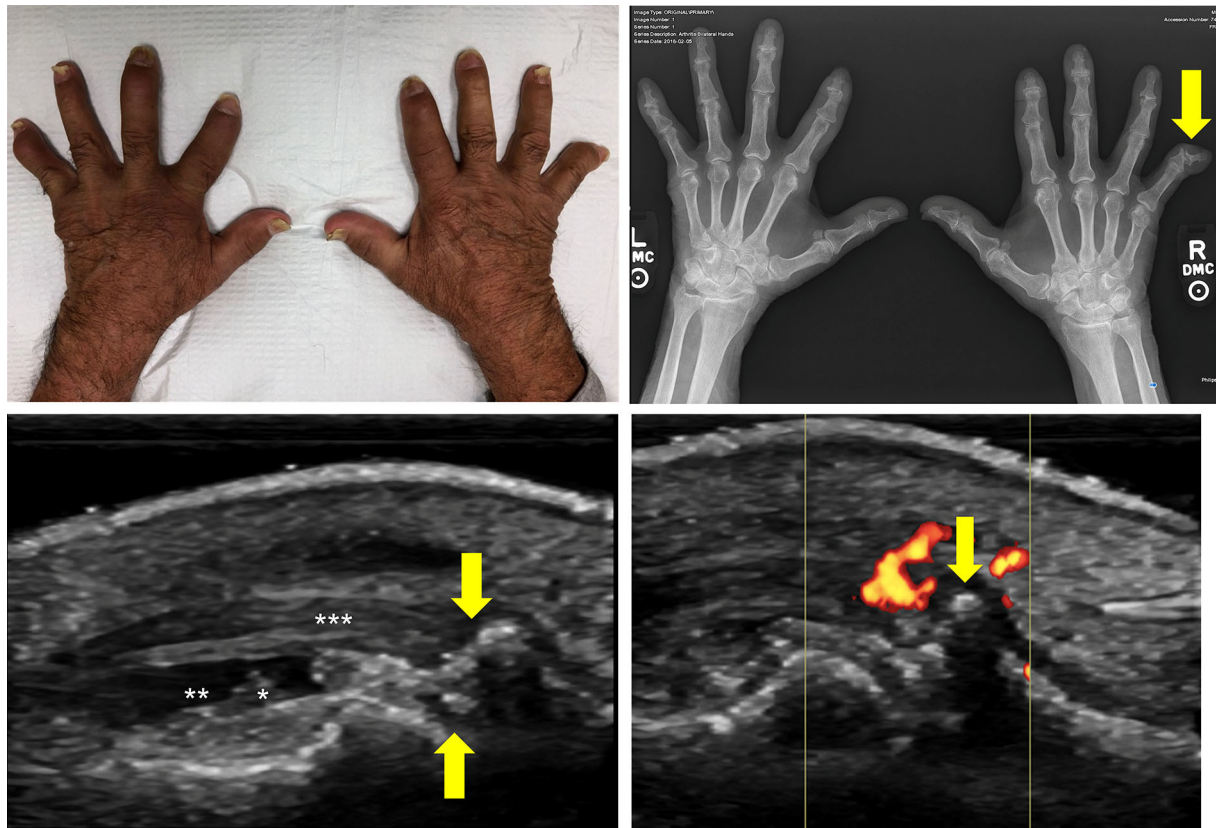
Clinical, radiographic, and ultrasound assessments in a patient with PsA. *Top left:* nail changes, dactylitis, and DIP subluxation as seen during clinical examination. *Top right:* conventional radiographs of the same patient exhibiting “wispy periostitis” and DIP subluxation (indicated by the *arrow*). *Bottom left:* ultrasound providing a longitudinal view of the DIP extensor tendon (indicated by the *triple asterisk*) showing enthesitis in the hand (extensive cortical irregularity indicated by the *downward*
